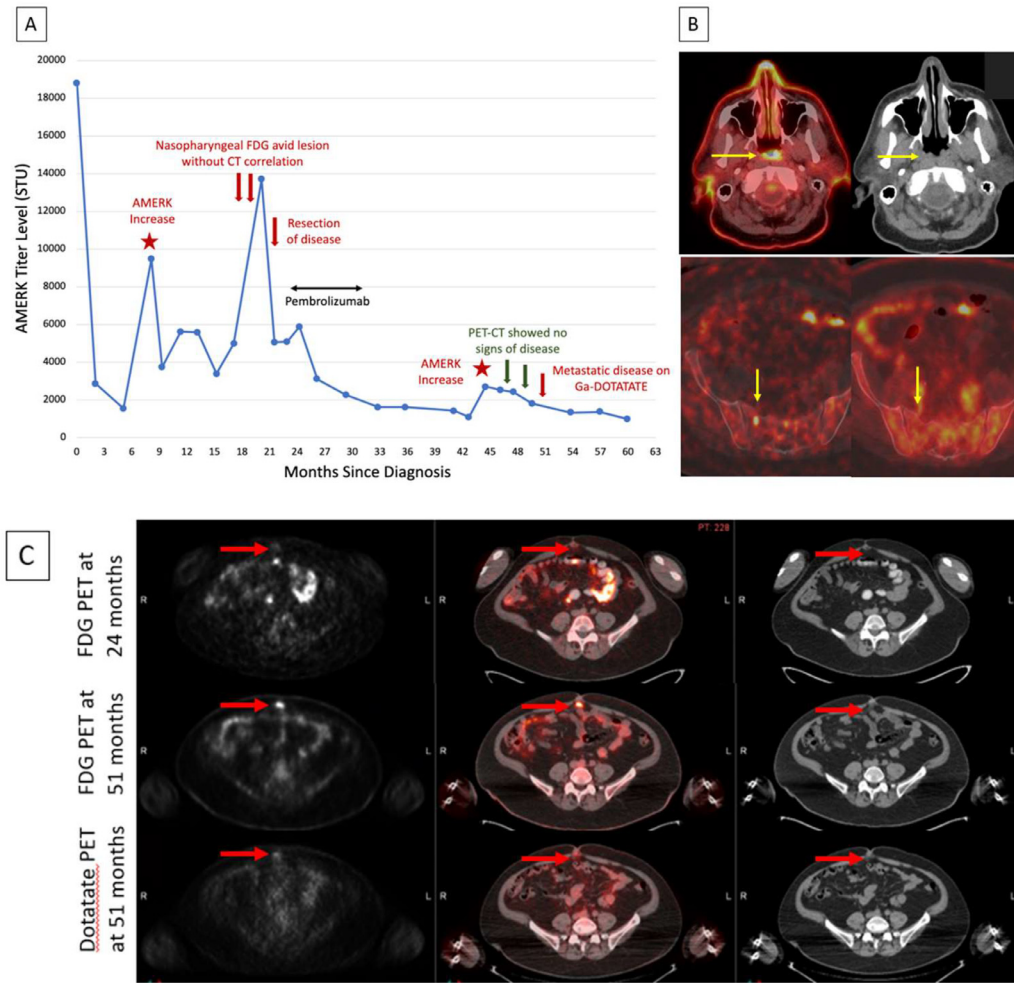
(A) AMERK titer over disease course. Note the marked increase in the titer nine months after the initial diagnosis and 8 months after the discontinuation of immunotherapy (44 months after the initial diagnosis). This increased titer eventually led to the detection of metastatic disease in subsequent imaging studies. (B, top row) ^{18}F -FDG PET-CT revealing nasopharyngeal disease (patient's first recurrence). Bottom left: ^{68}Ga -DOTATATE reveals S2 bone marrow involvement of the second recurrence. Bottom right: ^{18}F -FDG PET-CT performed around the same time showed only subtle involvement of the bone marrow. (C, top row) Retrospective review of the ^{18}F -FDG PET-CT scan obtained at the time of nasopharyngeal recurrence showed minimal uptake in fat stranding near the umbilicus (red arrows), middle row: that increased in intensity on ^{18}F -FDG PET-CT obtained shortly before the ^{68}Ga -DOTATATE imaging. Bottom row: ^{68}Ga -DOTATATE that was also showed mildly increased uptake at this site, identifying this as a site of MCC recurrence. Notably, the CT appearance of subtle fat stranding, atypical for recurrences that more typically look like solid nodules, did not change over this time period.
